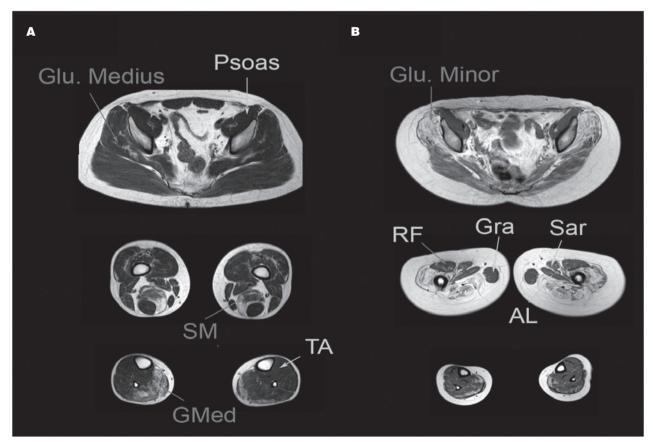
Muscle MRI of two patients with mutations in the LMNA gene. A) Patient with mild weakness. In this patient we observed fatty infiltration in the gluteus medius, semimembranosus (SM) and gastrocnemius medialis (GMed) muscles. B) Patient with severe weakness: fatty infiltration was observed in gluteus minimus and medius. All the muscles of the thighs were involved, except rectus femoris (RF), adductor longus (AL), sartorius (Sar) and gracillis (Gra) that were not atrophic.
